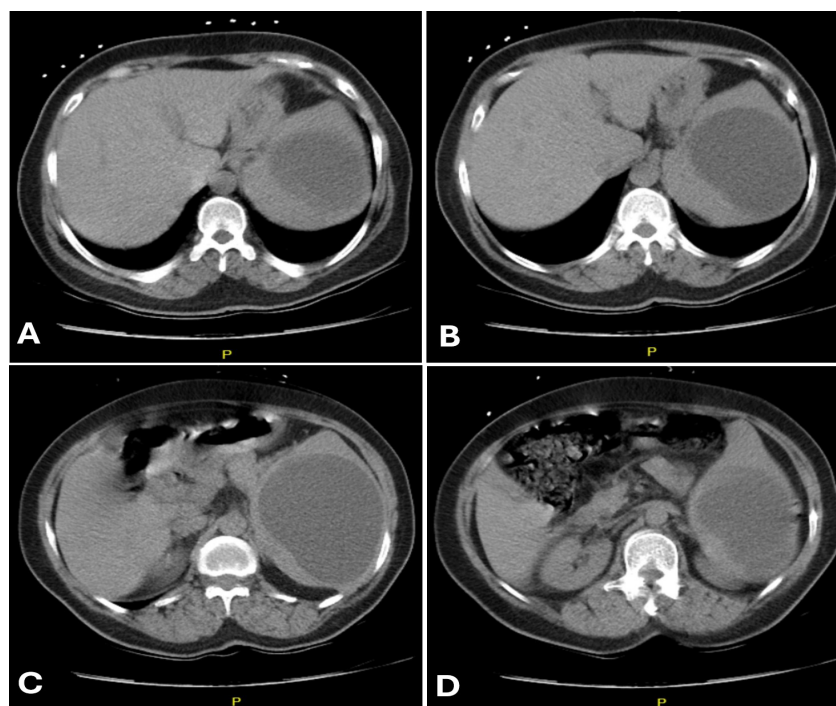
Axial (transverse) CT scan of the abdominal cavity shows an isolated, large, well-defined, round, hypodense and uniform fluid-density cystic lesion throughout the length of the spleen, without calcifications, a solid tissue component, or septations, suggestive of a splenic hydatid cyst. The germinal layer is intact, and there is no sign of cyst rupture. There are no signs of other organ involvement, importantly, the liver and lungs
